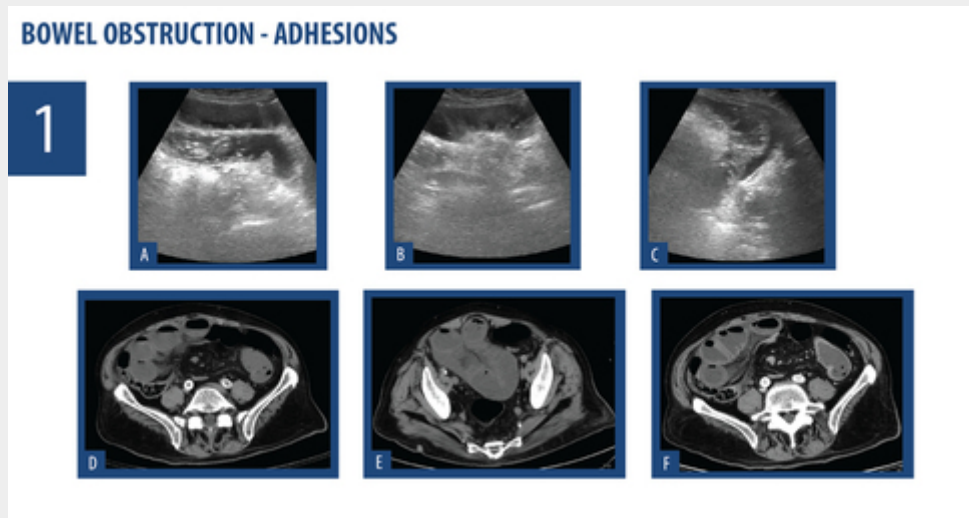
80 year-old patient presenting with diffuse abdominal pain. This patient had a recent history of abdominal surgery. On US (A,B,C) there was small bowel distention, with some degree of wall thickening and fluid distended loops. No cause of obstruction was identified. On CT (D,E,F) there is a "whirling" of the mesentery and vascular engorgement. No cause for obstruction was identified, and given the recent history of surgery, this patient was diagnosed with adhesions, surgically confirmed.
